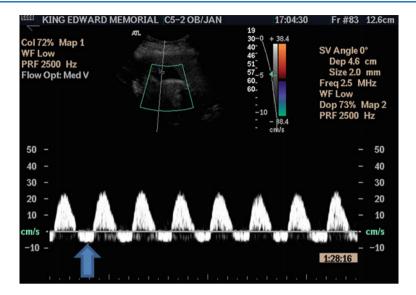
Abnormal UA Doppler: reversed flow in the umbilical artery Doppler. Arrow reversal of diastolic flow. Published with permission, courtesy of Dr. EF Magann
